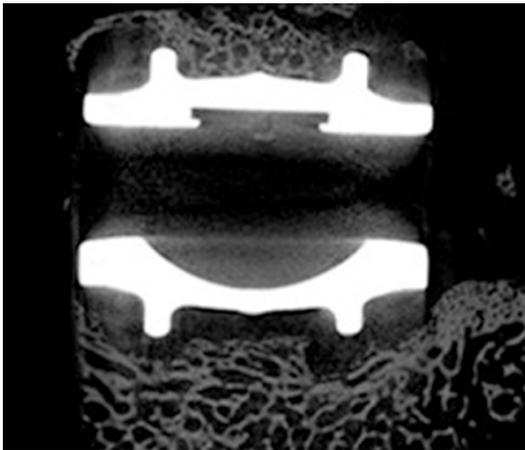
Microcomputed tomograph of the operative segment. Excellent ingrowth is seen at the prosthesis-bone interface 6 months after surgery.
